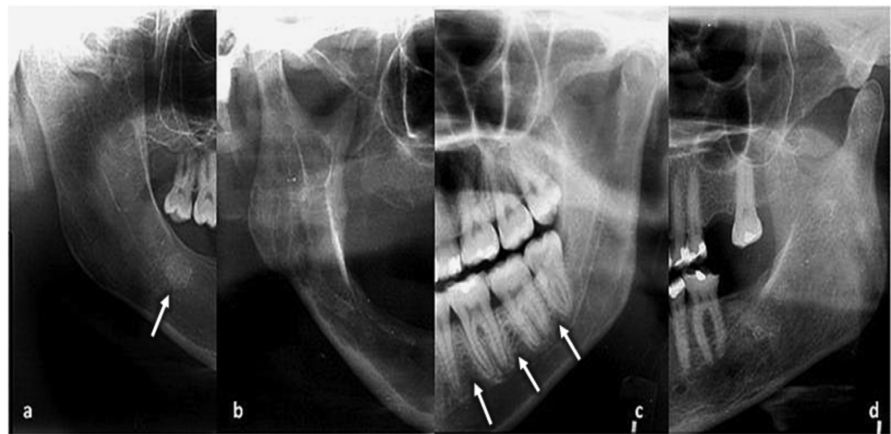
Cropped panoramic radiograph showing bone changes in sickle cell patients [13]. a. Radiopaque area; b. Spacing of bone trabeculae; c. Horizontal arrangement of bone trabeculae; d. Absence of corticalization of the mandibular canal.
